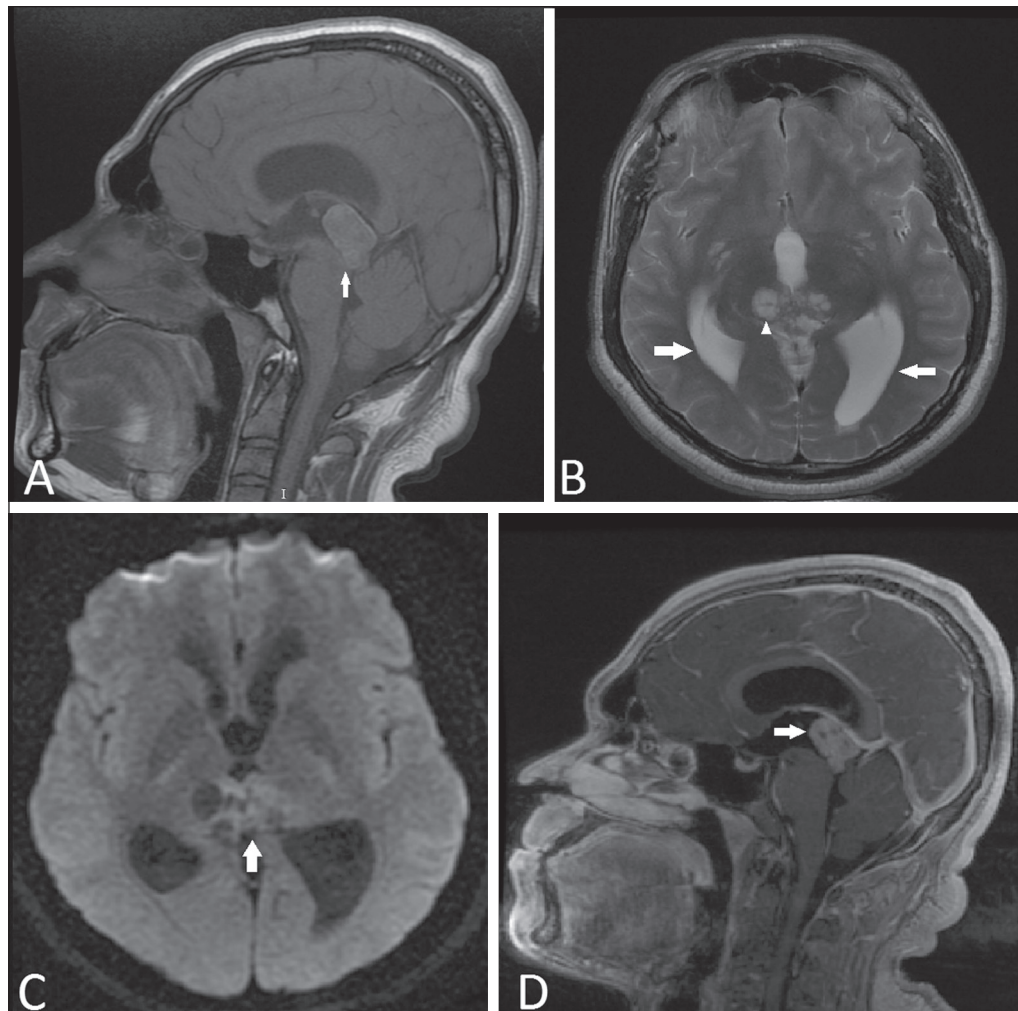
Magnetic resonance imaging. A: Non-contrast-enhanced sagittal T1-weighted sequence showing an expansile lesion in the pineal region compressing the dorsal midbrain and presenting a predominance of high signal intensity (arrow). B: Axial T2-weighted sequence showing cystic images within the lesion (arrowhead). Note also the increase in the dimensions of the supratentorial ventricular system (arrows). C: Functional diffusion-weighted sequence, axial section, showing discrete hyperintensity. D: Gadolinium contrast-enhanced sagittal T1-weighted sequence showing heterogeneous enhancement.
